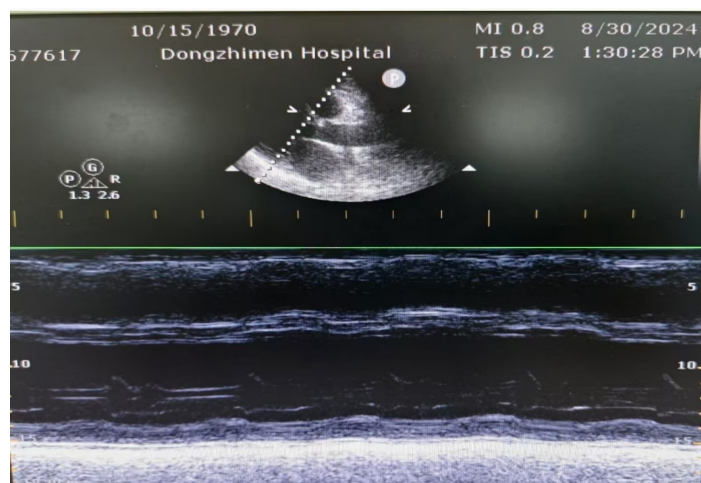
Echocardiogram on admission
